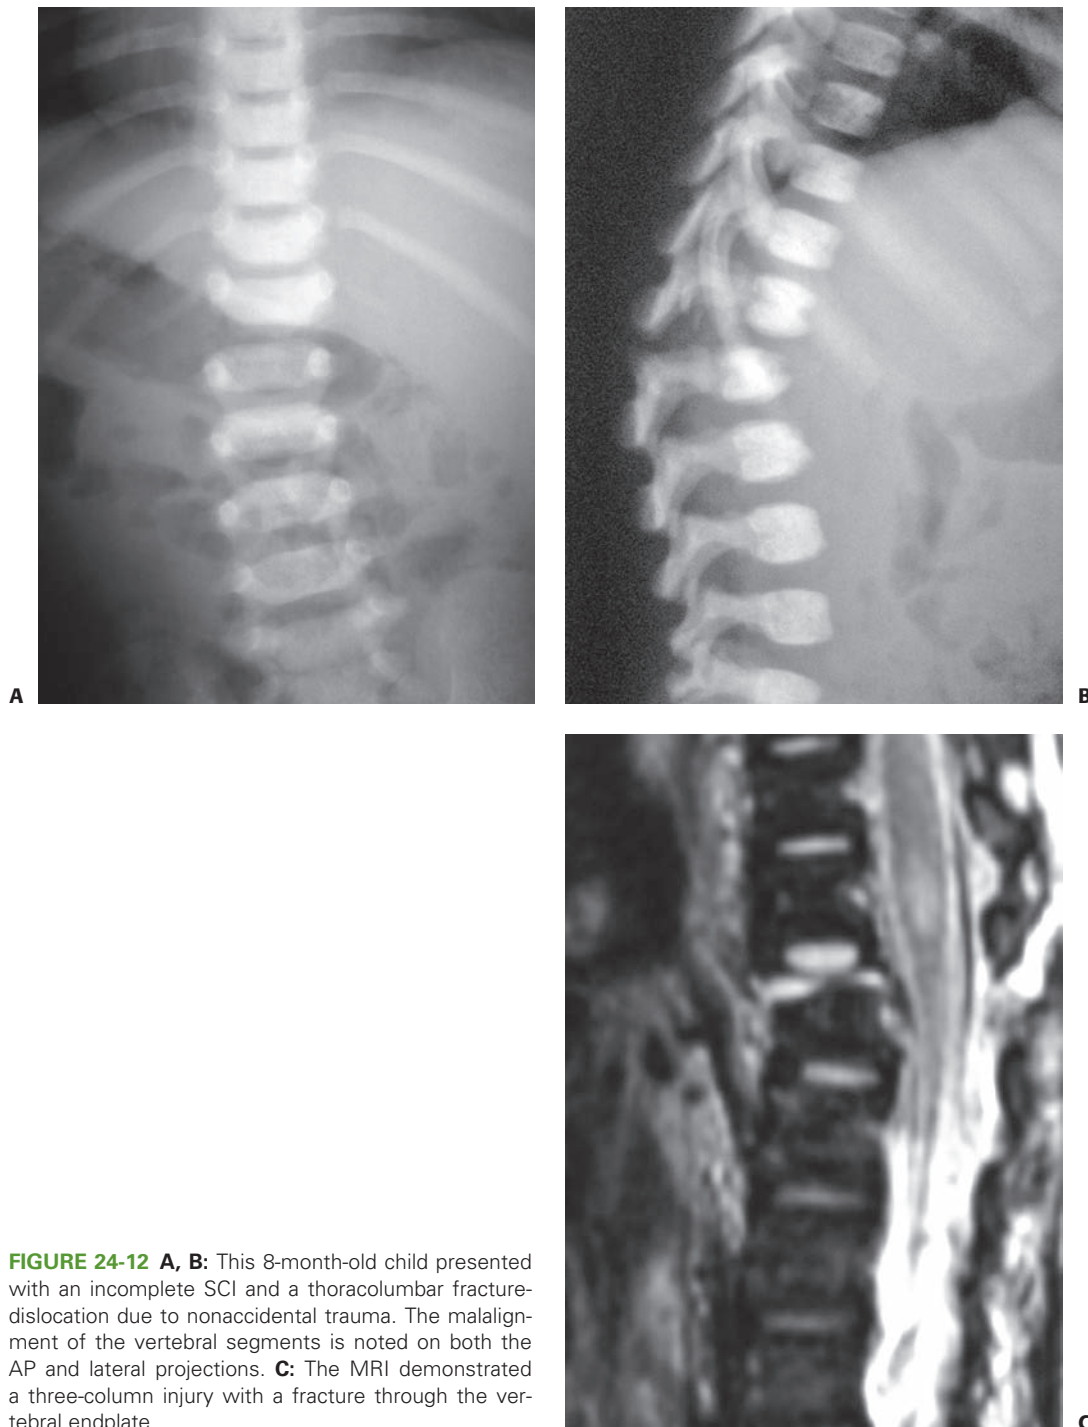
A, B: This 8-month-old child presented with an incomplete SCI and a thoracolumbar fracture-dislocation due to nonaccidental trauma. The malalignment of the vertebral segments is noted on both the AP and lateral projections. C: The MRI demonstrated a three-column injury with a fracture through the vertebral endplate.
